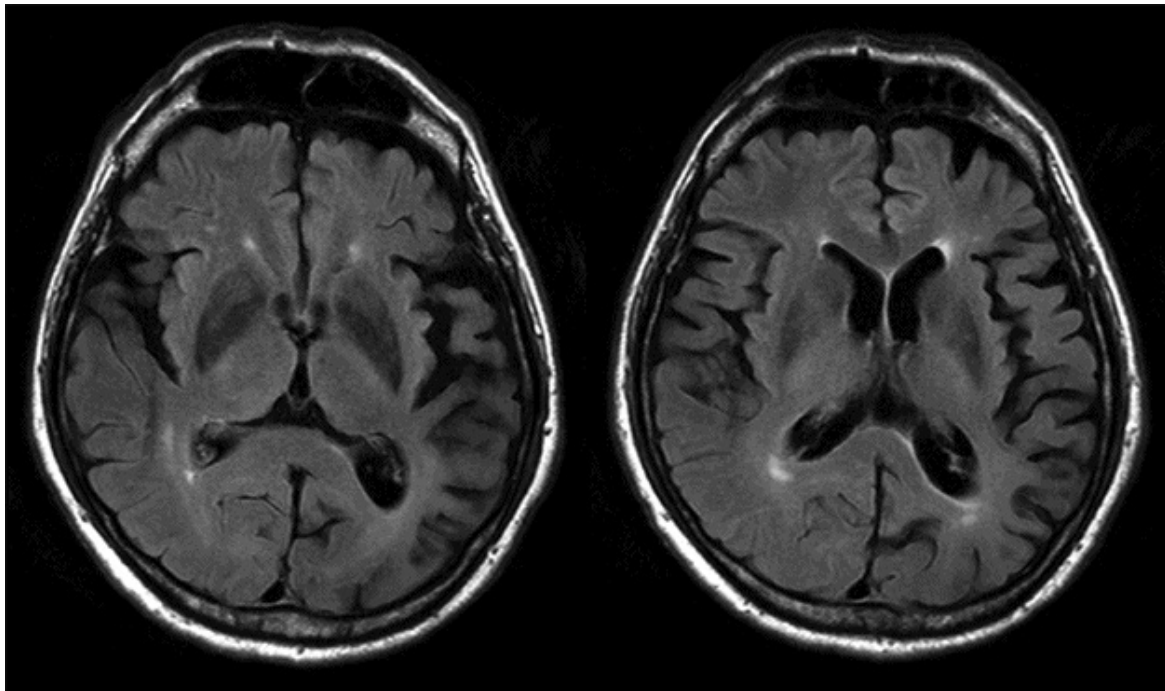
Axial T2-weighted fluid-attenuated inversion recovery (FLAIR) scans of a 56-year-old patient affected by nvPPA, showing an enlargement of the left lateral ventricle and the frontal subarachnoid spaces bilaterally, and a widening of the left sylvian fissure resulting in a pattern of prevalent left-sided perisylvian atrophy. Images are displayed in radiologic convention (i.e., left = right; right = left).
